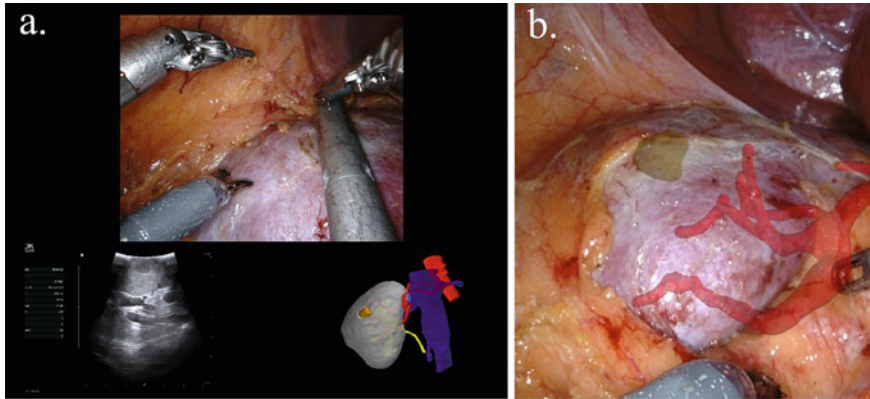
a. Virtual model input using TilePro™, shows a partially endophytic tumour. Ultrasound confirms the location of the tumour. Figure 8.b. Augmented reality setting in which the same 3D model is overlapped to the endoscopic view, also showing the location of the arteries and invisible endophytic part of the tumour. It is to be noted that this is also inputted using the TilePro™ function, as the current systems do not allow to take over the main console view
